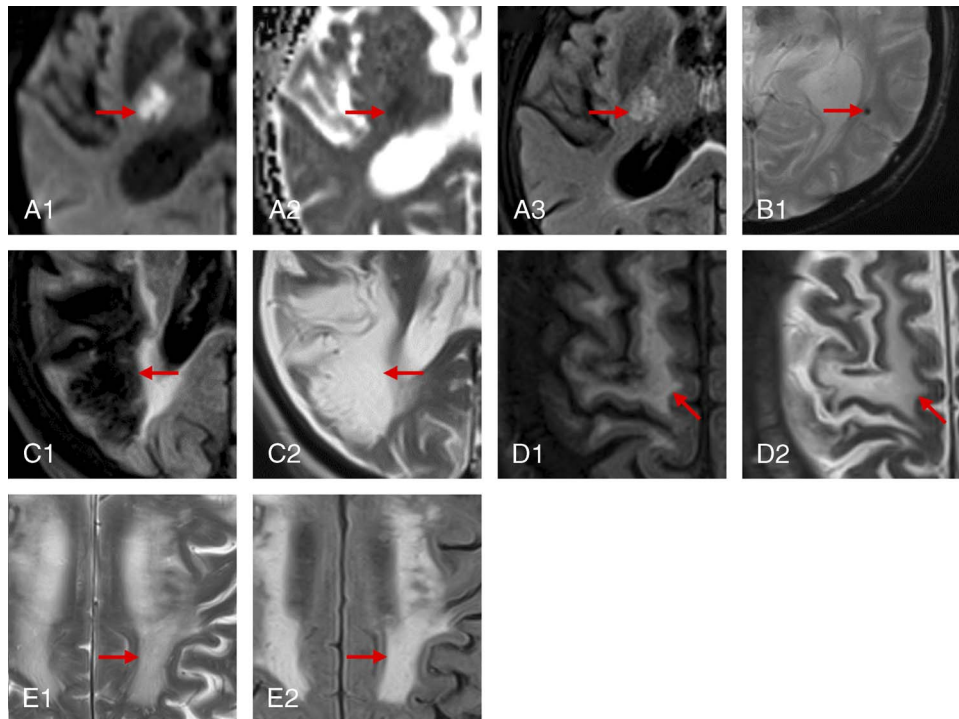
Intracranial pathology categories. Representative images. Pathologies indicated by arrows. A, Acute ischemia, hyperintense in diffusion-weighted imaging (DWI, A1), hypointense in ADC (A2), hyperintense in fluid-attenuated inversion recovery (FLAIR, A3). B, Microbleed, T2*-hypointense. C, Chronic infarction: cystic transformation hypointense in fluid-attenuated inversion recovery (FLAIR, C1) and hyperintense in T2 (C2). Note the isointense gliotic rim (C1), D, Edema, hyperintense in both fluid-attenuated inversion recovery (FLAIR, D1) and T2 (D2). E, White matter lesions: confluent T2 (E1) and fluid-attenuated inversion recovery (FLAIR, E2) hyperintense lesions.
